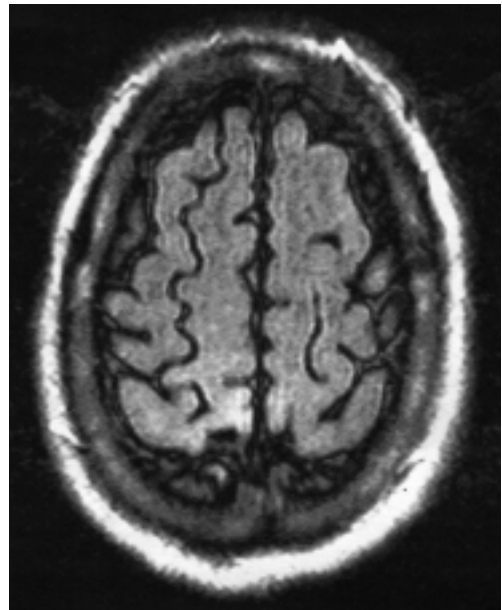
Slight hyperintensity at the level of the right perirolandic cortex better shown on the FLAIR image.
